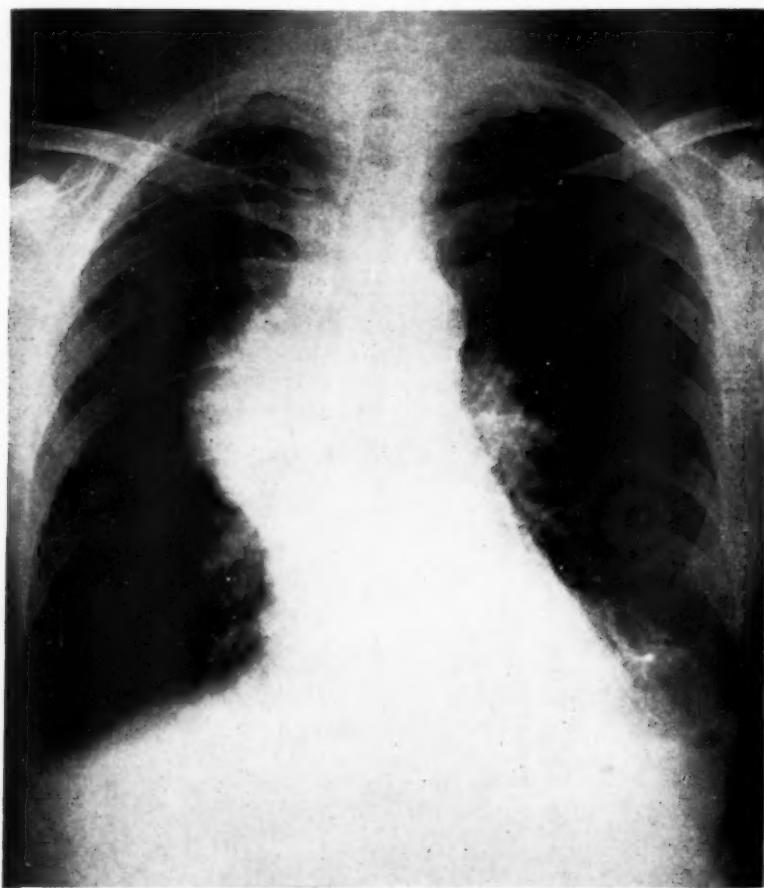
X-ray film of chest. The mass in the region of the ascending aorta was seen to pulsate on fluoroscopy. Note the small collection of fluid at both lung bases.
